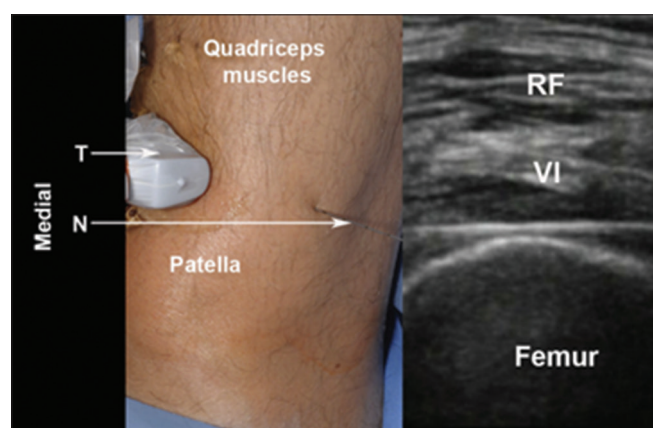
Ultrasound-guided local infiltration. N: Needle; RF: Rectus femoris muscle; T: Transducer (linear, high frequency); VI: Vastus intermedius muscle (Source: R. O'Donnell and J. Dolan* Anaesthesia and analgesia for knee joint arthroplasty. BJA Education, 18(1): 8e15, 2018)
